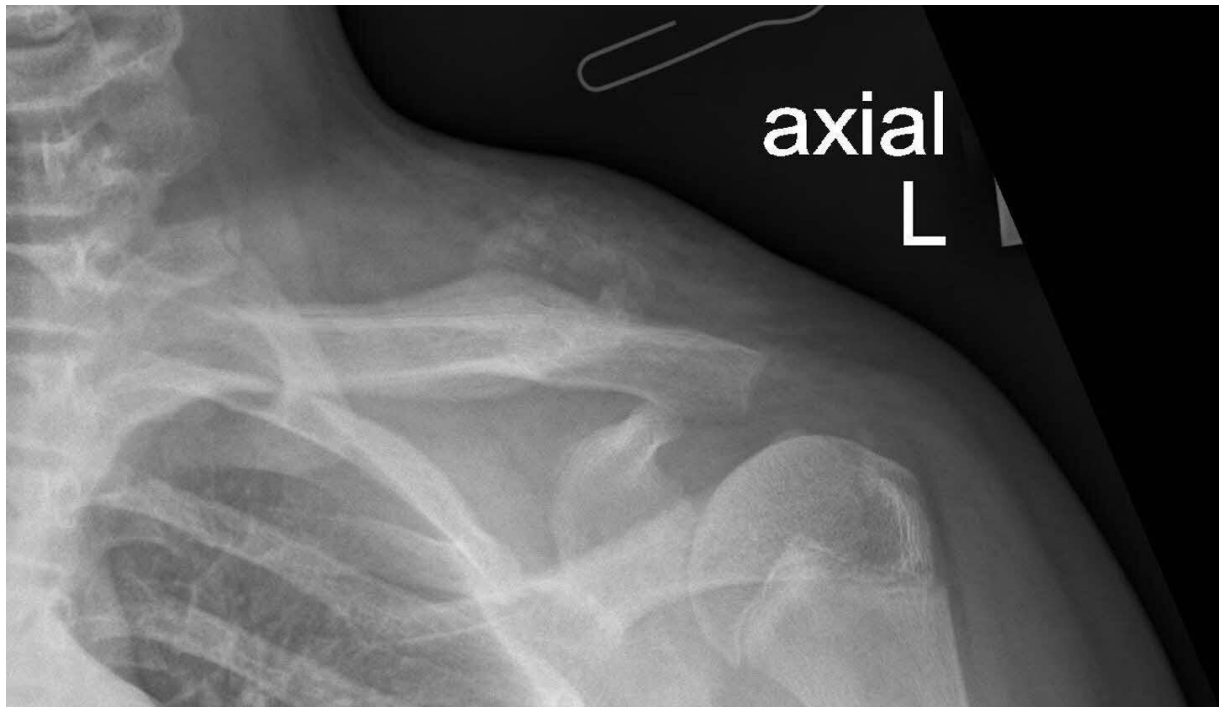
Axial radiography of the left clavicle showing a calcified mass.
